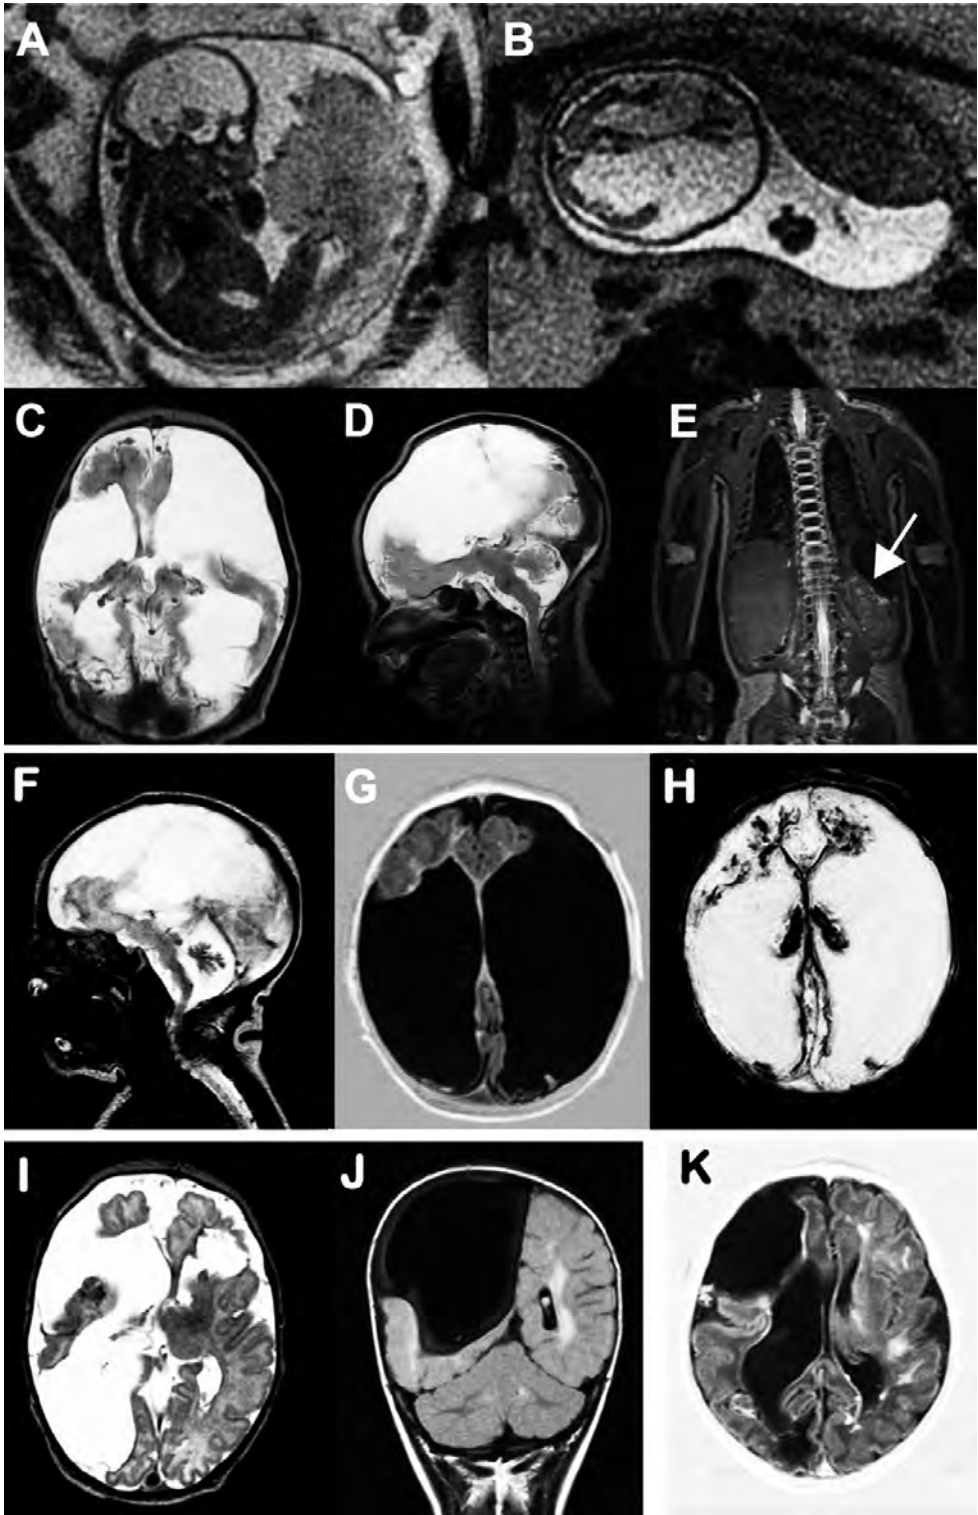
Magnetic resonance imaging (*opposite page*)
